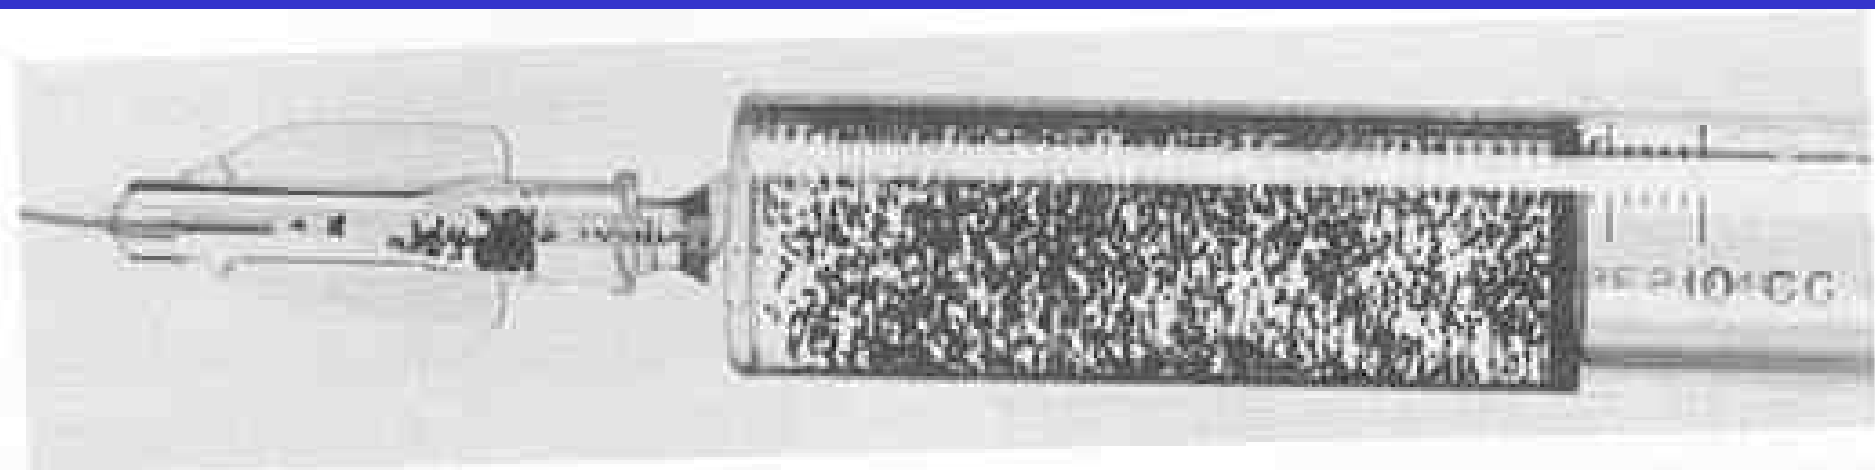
Pulsar embolization particles (Medtronic/MIS), which are optically and radiographically visible.
